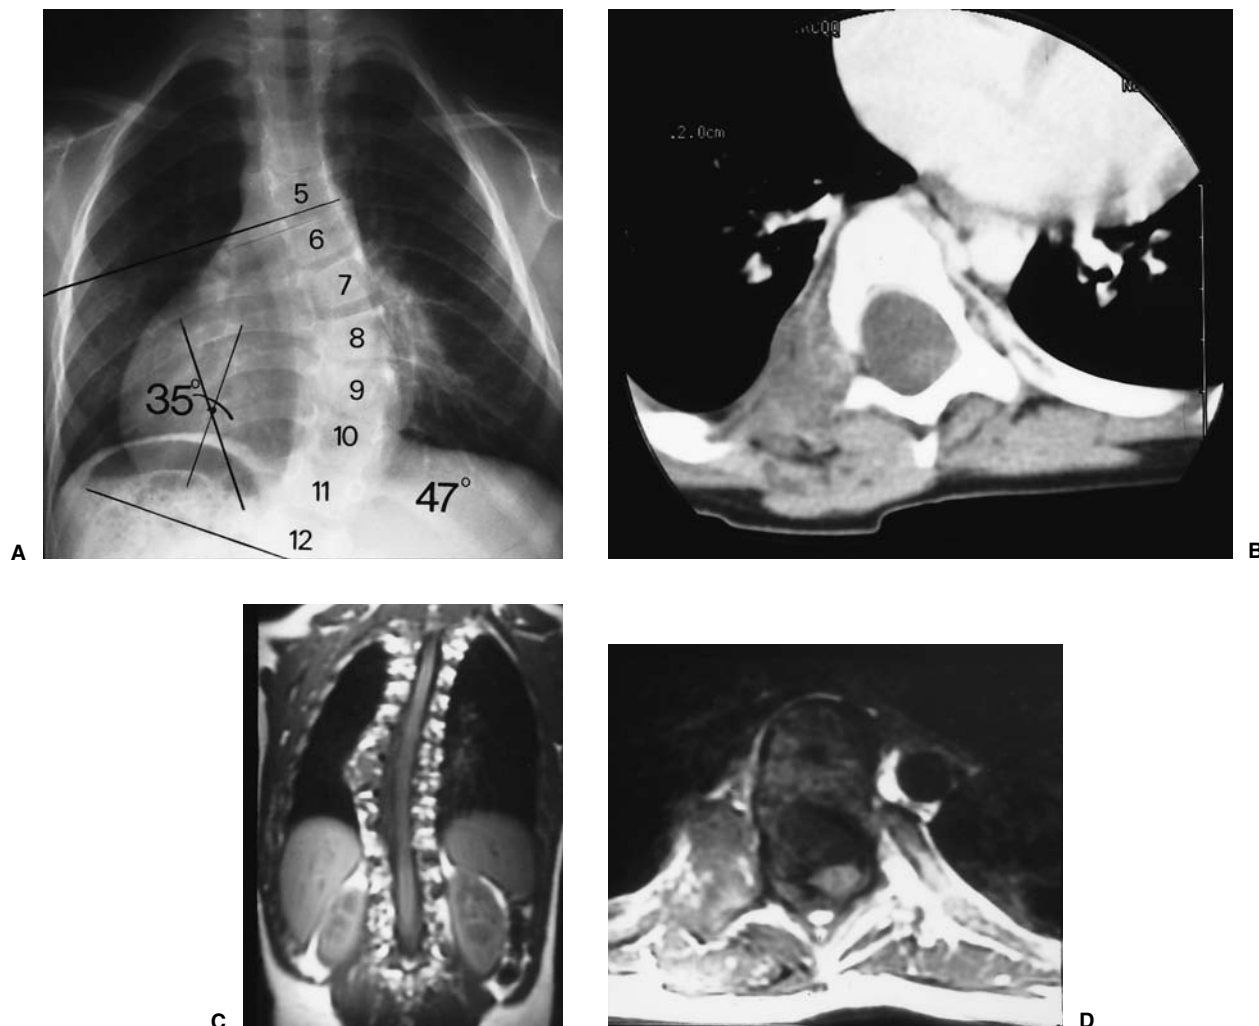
This 3-year-old girl's father had a history of neurofibromatosis type I. Her parents noted her progressive scoliosis. The spine radiograph viewed from the back (A) showed a 35-degree right-side convexity curve. It also showed thinning of the pedicle at T-7, T-8, and T-9 on the right greater than on the left. Her body CT scan (B) and MR images (C,D) revealed an epidural mass extending
